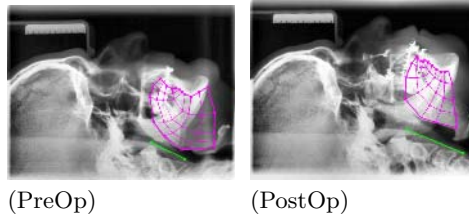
Segmentation of the pre-operative (*PreOp*) and the post-operative (*PostOp*) radiographies of apneic patient no. 1. The initial mesh and the borders of the tongue are displayed in purple, while the posterior pharyngeal wall is in green.
